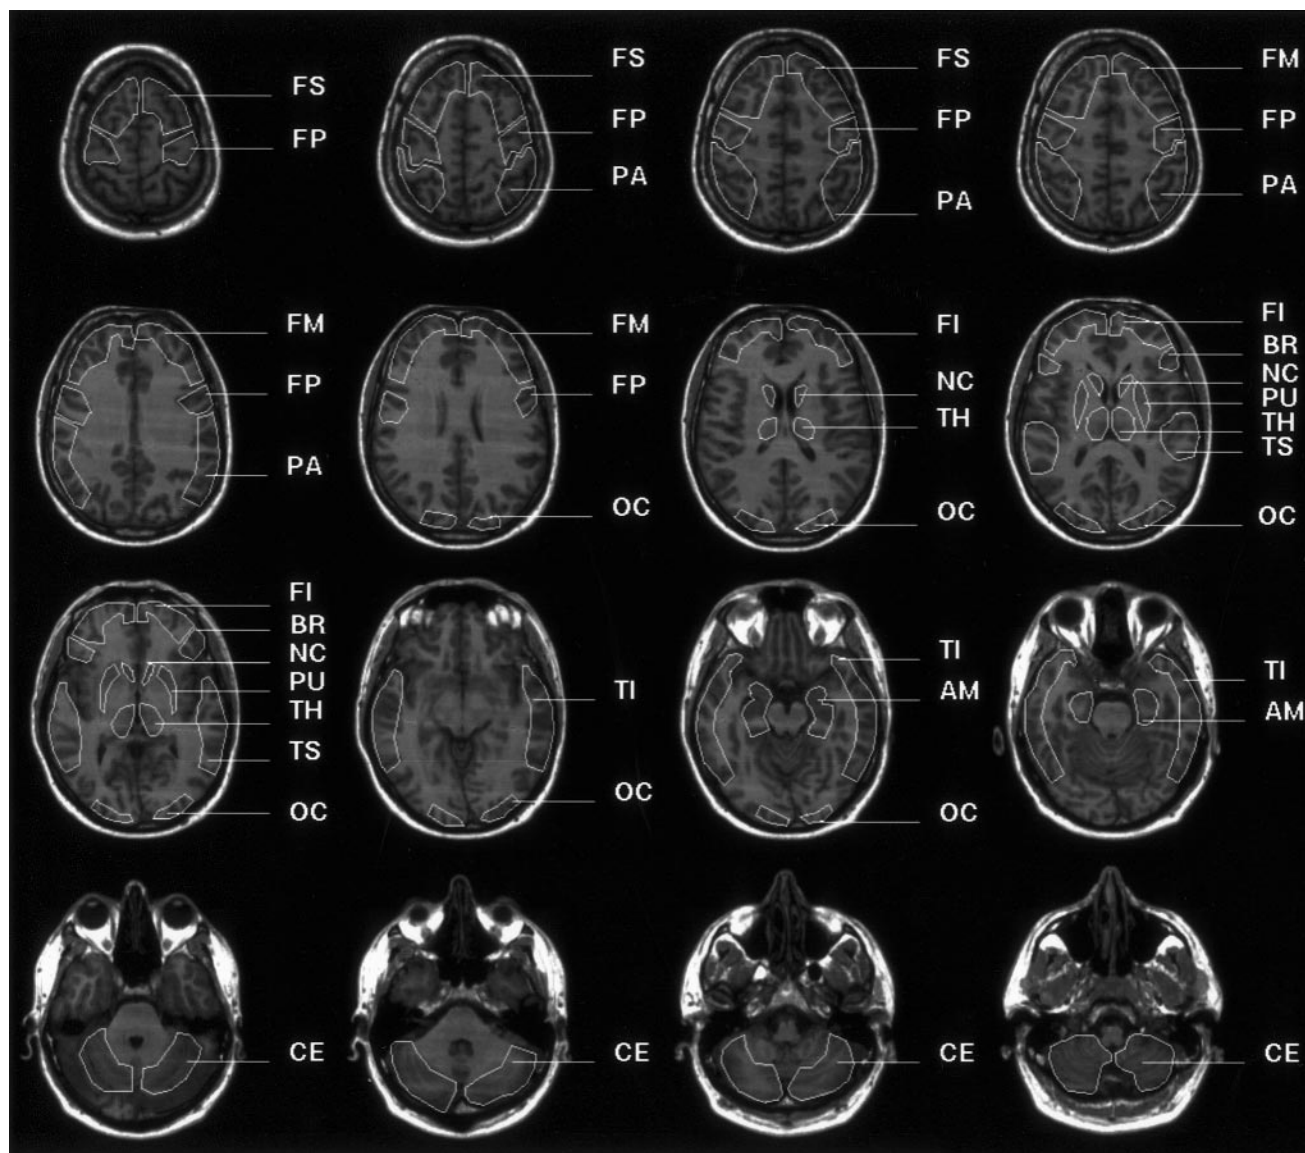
Transaxial MRI slices of one subject with the manually defined regions of interest superimposed on individual PET slices after PET/MRI realignment (FS prefrontal superior, FM prefrontal middle, FI prefrontal inferior, BR frontal operculum, FP frontal posterior, TS temporal superior, TI temporal inferior, PA parietal, OC occipital, CE cerebellum, NC caudate nucleus, PU putamen, TH thalamus, AM amygdala, CA cingulum anterior, CM cingulum middle, CP cingulum posterior)
